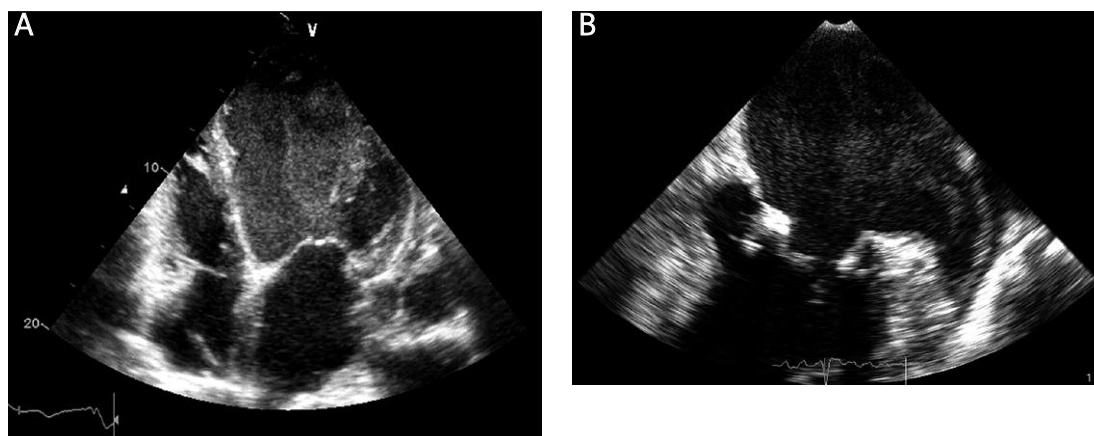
A – Transthoracic two-dimensional echocardiography, apical-four chamber view in a patient with dilated cardiomyopathy – SEC in dilated left ventricle. B – Transesophageal two-dimensional echocardiography in a patient with mitral stenosis – SEC in dilated left atrium
